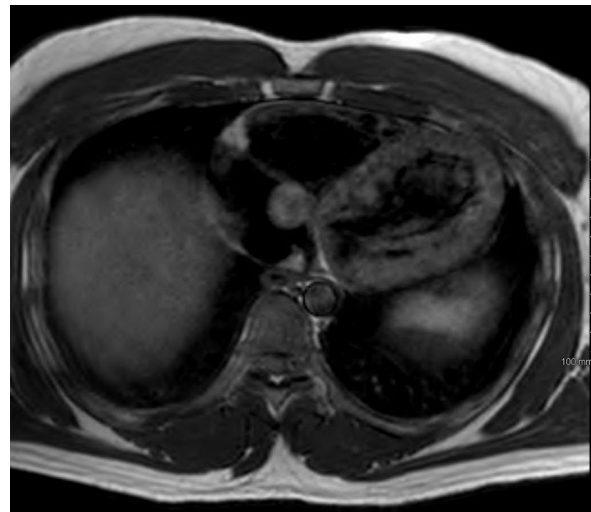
Cardiac magnetic resonance image shows a right atrial mass, with a well-defined, smooth margin, immediately inferior to the noncoronary sinus of Valsalva.
